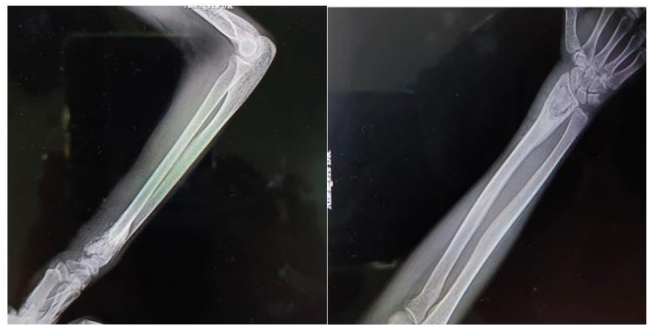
Immediate postoperative (A) AP and (B) lateral x-rays
